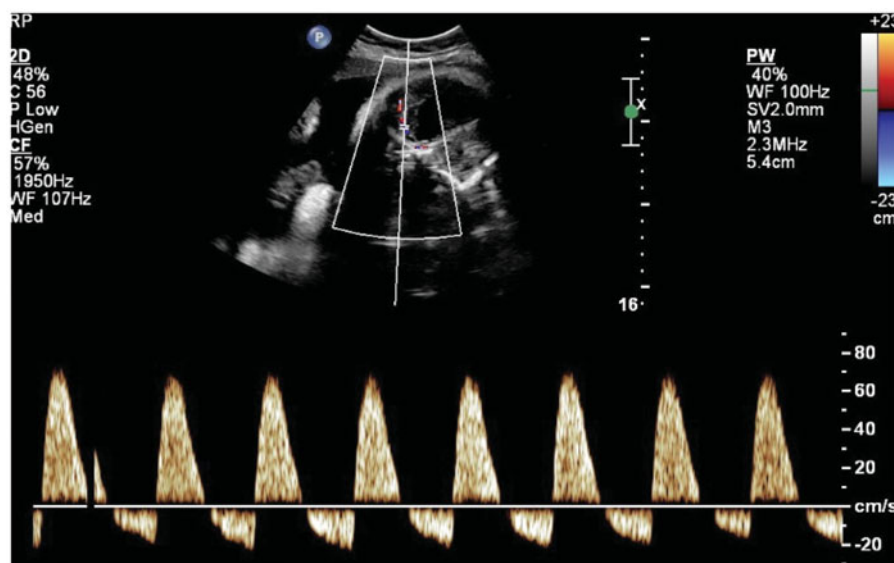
Reversed diastole of middle cerebral artery Doppler.
